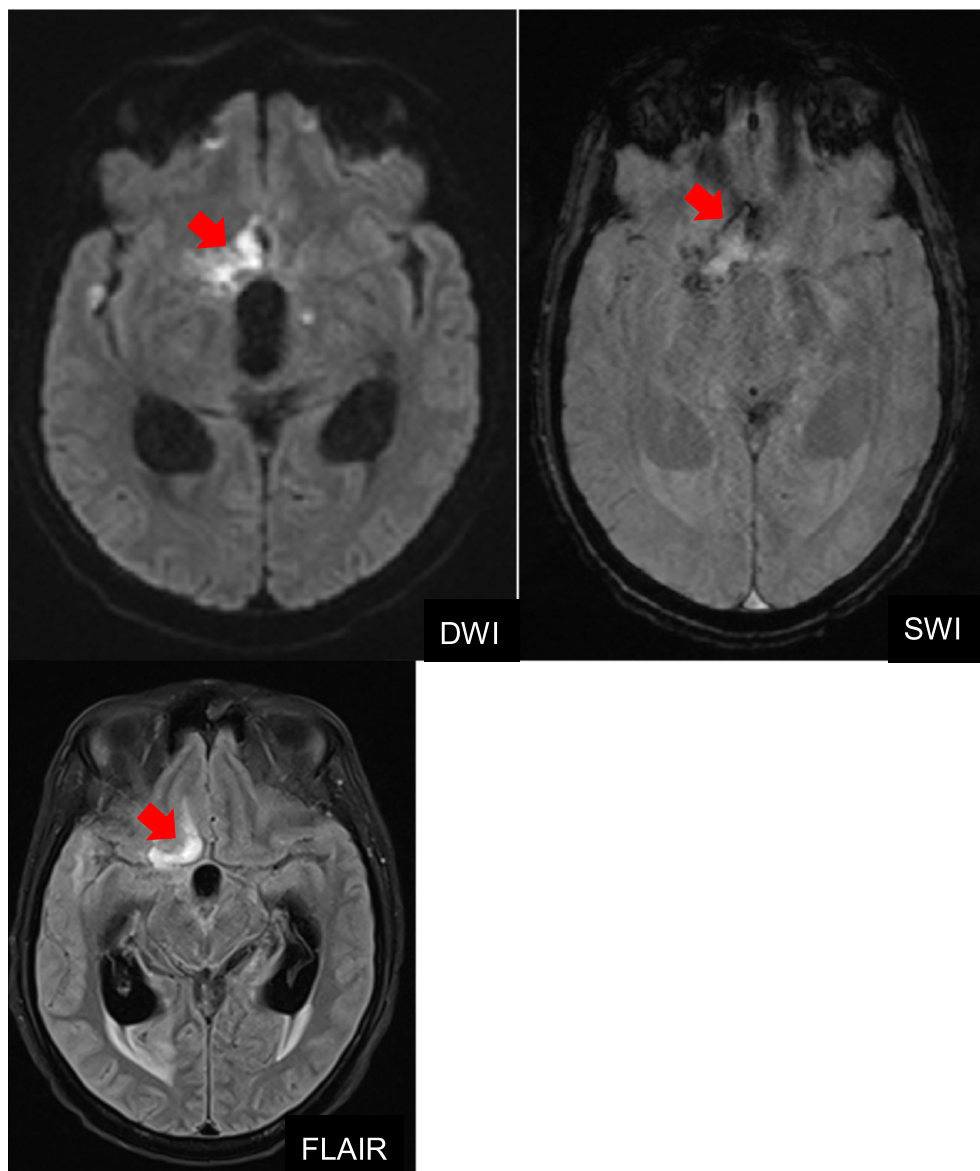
FLAIR hyperintensity with restriction of diffusion and blooming on SWI to suggest infarction with hemorrhagic transformation in the right basifrontal lobe (secondary to vasculitis). Dilated ventricles are suggestive of hydrocephalus.
